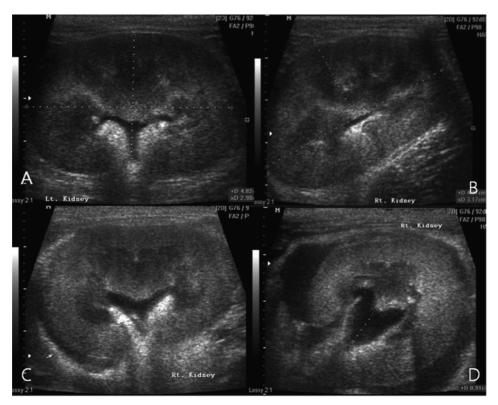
Serial ultrasonographic assessment of the kidneys after admission. A, B (Day 1); enlarged bilateral kidneys (left kidney: 4.82×2.98 cm, right kidney: 4.97×3.17 cm) with mild pelvic dilation were showed on the first day of admission. C (Day 8); one week after hospitalization, a small amount of hypoechoic fluid was seen around the right kidney and there is also mild pelvic dilation. D (Day 10); the amount of hypoechoic fluid was increased within the thickened renal capsule.
